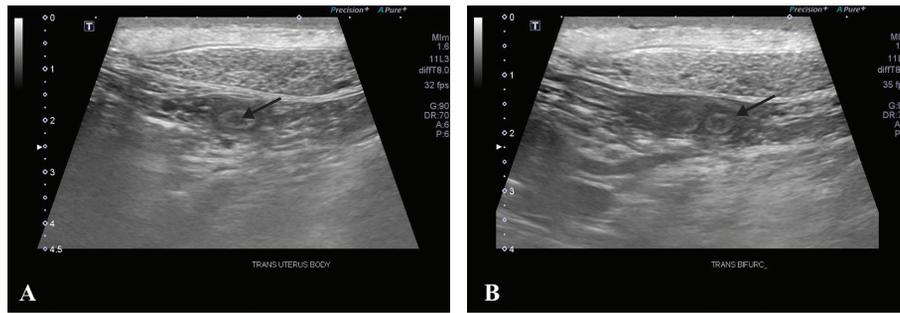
Ultrasonographic images of uterus on day 30: A. transverse view of uterine body and B. uterine horn bifurcation (characteristic of cystic endometrial hyperplasia) cysts; note cysts (arrows) within uterine endometrial lining.
